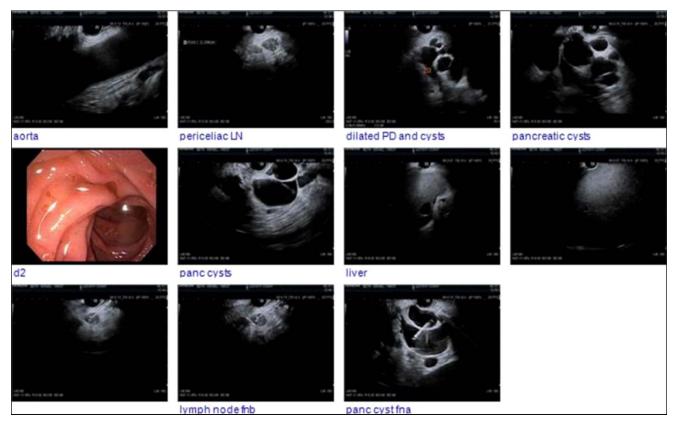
Endoscopic ultrasound showing a massively dilated pancreatic duct and numerous large cysts. The largest cyst measured approximately 4 cm in the head/neck. No discrete pancreatic mass is seen.
